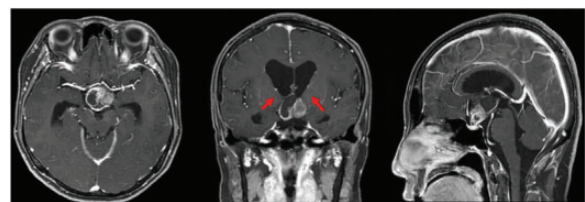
Neuroimaging findings. Brain MRI (T1 contrast-enhanced images) reveals a 4 cm sized lobulating solid and cystic mass with rim enhancement and calcification in the suprasellar cistern. The mass has a core of T1 high signal intensity and thin wall enhancement. There is no attachment or compression of midbrain. The superior dominance was related to upward extension of the cystic portion to the 3rd ventricle with presumed elevation of the 3rd ventricle floor, resulting in obstructive hydrocephalus (red arrows). These MR findings indicate that the mass pathology is probably craniopharyngioma.
